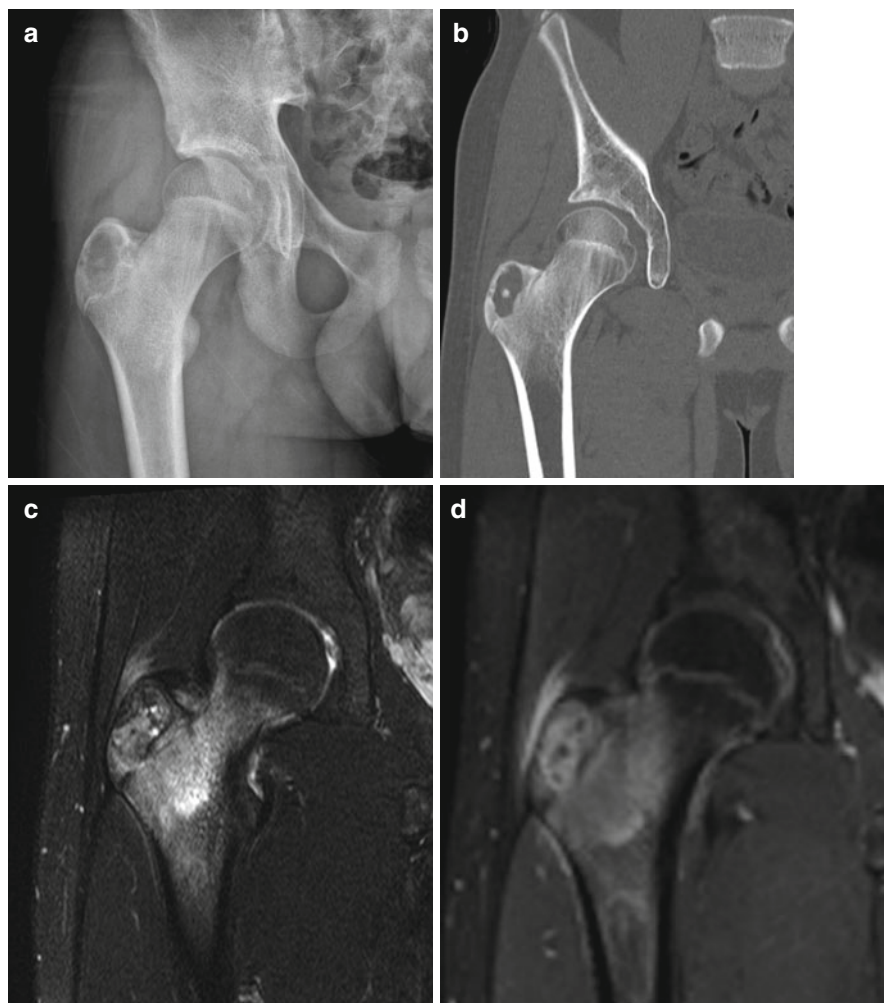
Chondroblastoma in a 15-year-old boy. (a, b) Plain radiography (a) and CT (b) show a well-demarcated osteolytic lesion in the right femur greater trochanter. Note the lesion involving the apophysis (analog to the epiphysis) and there is no cortical bone disruption. (c, d) MR fat-suppressed T2-weighted image (c) and postcontrast
